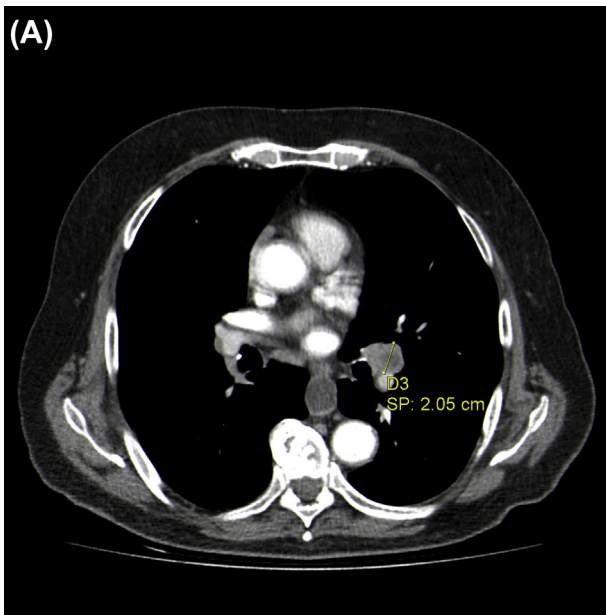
Enlarged hilar lymph node at baseline CT (A) with decrement to normal size after 16 cycles of pembrolizumab (B) (marking D7 with diameter in centimetres). CT, computed tomography.
